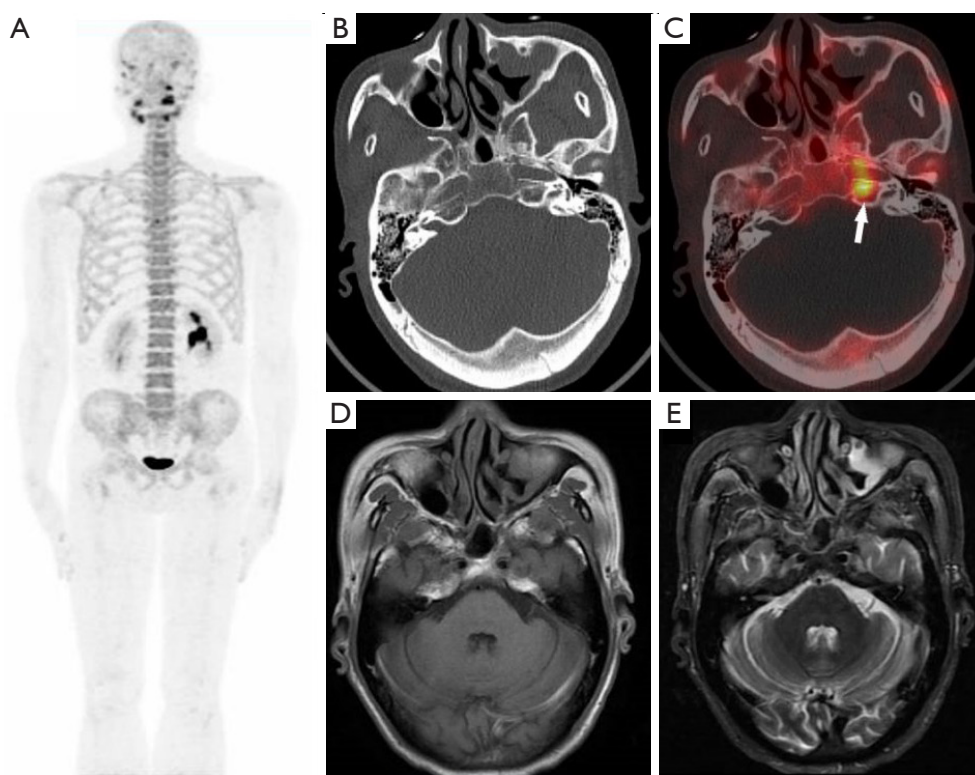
A 46-year-old male patient with NPC who underwent staging evaluation. Initial ^{18}F -NaF PET MIP imaging (A) did not reveal any evidence of bone metastasis. CT imaging (B) and subsequent ^{18}F -NaF PET/CT fusion imaging (C, arrow) demonstrated abnormal accumulation in the petrous part of the left temporal bone suggestive of SBBI by NPC. MRI with T1-weighted imaging (D) and T2-weighted imaging (E) did not reveal any abnormal signals in the skull base bone. Based on the MRI findings, the patient was initially classified as T2 stage NPC. However, upon the integration of the ^{18}F -NaF PET/CT and MRI data, the tumor staging was revised to T3. NPC, nasopharyngeal carcinoma; ^{18}F -NaF PET/CT, ^{18}F -sodium fluoride positron emission tomography-computed tomography; MIP, maximum intensity projection; CT, computed tomography; SBBI, skull base bone invasion; MRI, magnetic resonance imaging; $^{99\text{m}}\text{Tc}$ -MDP, $^{99\text{m}}\text{Tc}$ -methylene diphosphonate.
